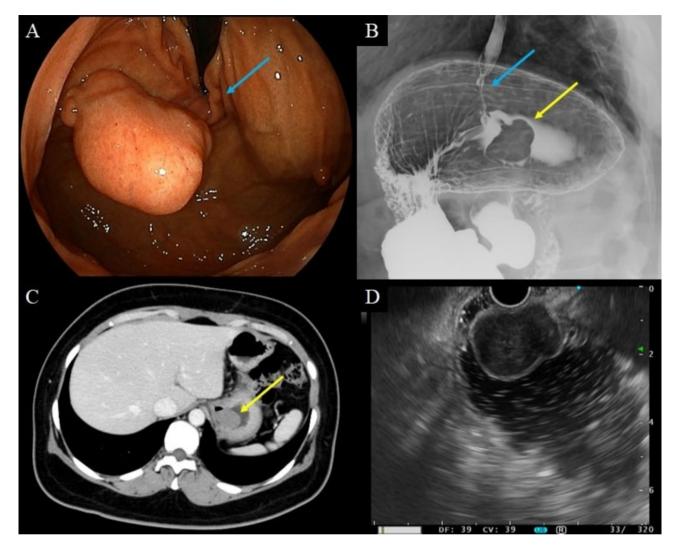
Preoperative examinations. A. Endoscopic findings on medical examination. A gastric submucosal tumor without ulceration, approximately 3 cm in diameter, was observed in the posterior wall of the upper gastric body near the cardia (blue arrow). B. Upper gastrointestinal contrast findings indicating a gastric submucosal tumor (yellow arrow) located near the cardia (blue arrow). C. Contrast-enhanced computed tomography image showing an intraluminal tumor (3 cm in diameter) in the stomach (yellow arrow). D. Endoscopic ultrasonographic findings showing a submucosal tumor originating from the fourth layer
